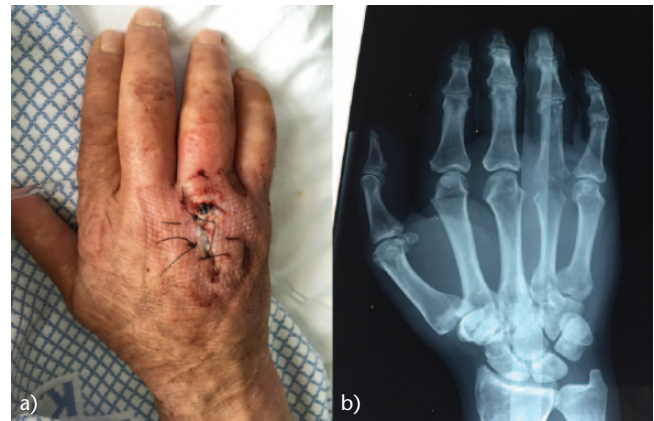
(a) Clinical photograph and (b) radiograph of the hand show septic arthritis of the fourth metacarpophalangeal joint after trauma.
